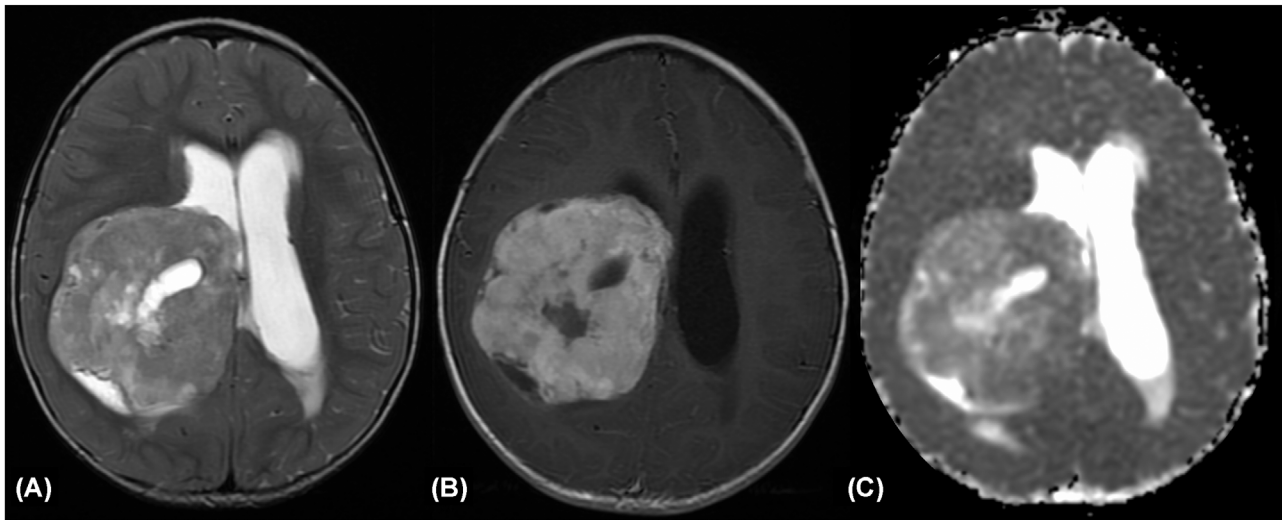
Supratentorial high-grade astroblastoma in a 1-year-old boy presenting with weakness of the left lower extremity (patient 7). The solid components of the tumor show high intensity on T2-weighted image (A) and low intensity on T1-weighted image (not shown) with heterogeneous enhancement (B). The mean apparent diffusion coefficient value is $1.02 \times 10^{-3} \text{mm}^2/\text{s}$ (C). The tumor shows a solid mass with internal cysts (morphology II)
